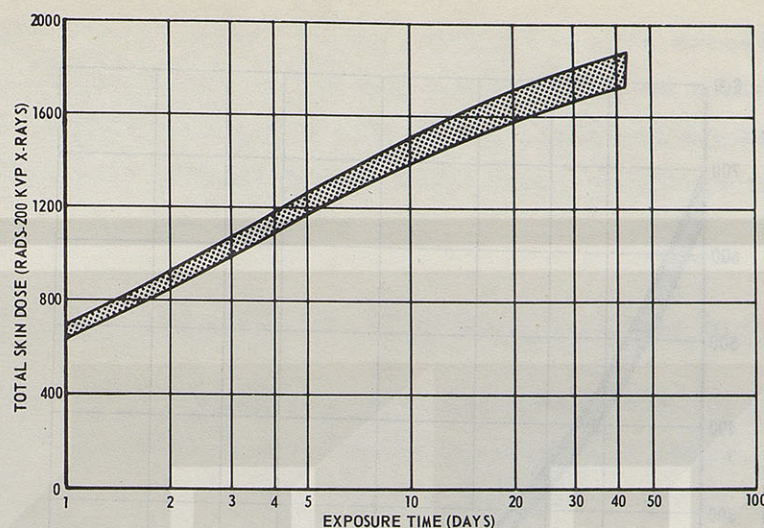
Total skin dose of 200 KVP x-rays, or a radiation with a QF of unity, required to produce a slight erythema as a function of time over which exposure is spread.
